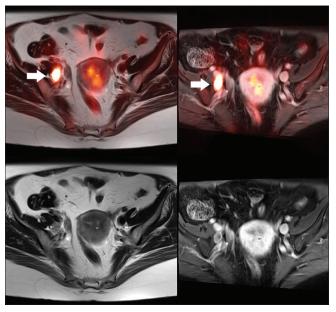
A 47-year-old female with squamous cell carcinoma of the exocervix. Dedicated pelvis imaging showing the same hypermetabolic right internal iliac lymph node (arrows) on T2-weighted fusion(top left) and T1-weighted volumetric interpolated breath-hold examination contrast-enhanced fusion images (top right). T2-weighted images showing the enlarged lymph node (bottom left) which demonstrates enhancement (bottom right)
